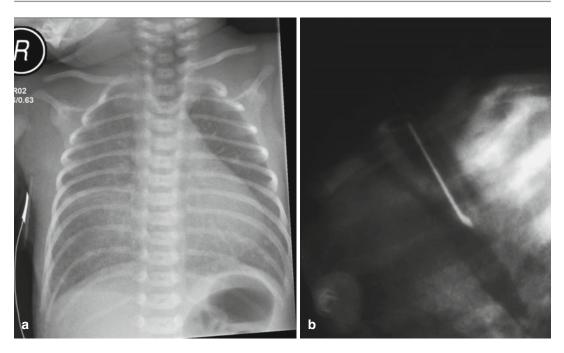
(a, b) Esophageal atresia with distal. (a) Initial radiograph with no enteric tube shows distension of the atretic esophageal pouch. (b) Tracheomalacia. Lateral
